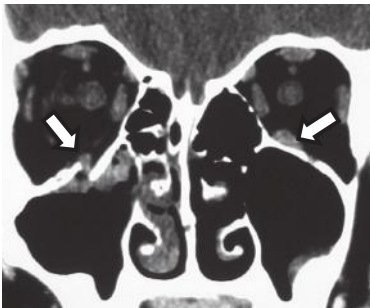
Coronal CT image showing pediatric orbital floor trapdoor fracture with entrapped inferior rectus muscle. The orbital floor in children tends to spring back to its anatomic location, trapping the inferior rectus muscle in the maxillary sinus. The orbital floor often appears normal, and thus the diagnosis can be easily missed. Notice the position of the entrapped inferior rectus muscle (*left arrow*) compared with the contralateral inferior rectus muscle (*right arrow*).
